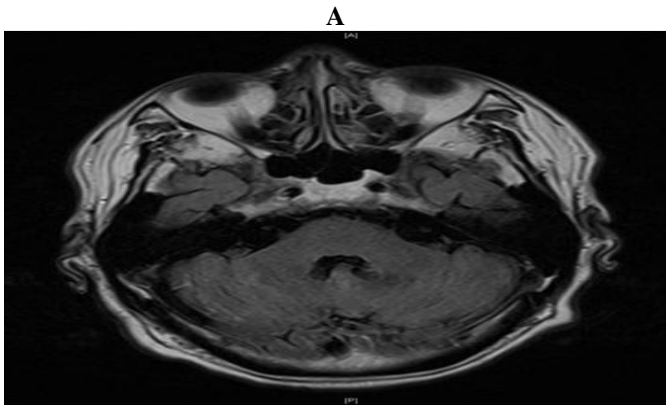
Follow-up MRI 27 days after metronidazole discontinuation. Complete resolution of the lesion over bilateral cerebellar dentate nuclei was noted in all sequences. T2 FLAIR image (A), T2-weighted image (B), T1 with gadolinium contrast (C), DWI (D), and ADC (E)
